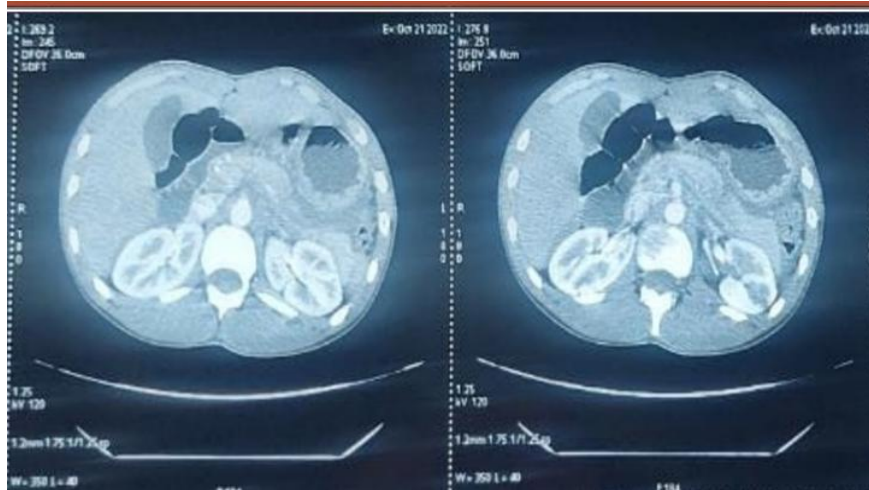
CT scan image showing the lesion of the pancreas
